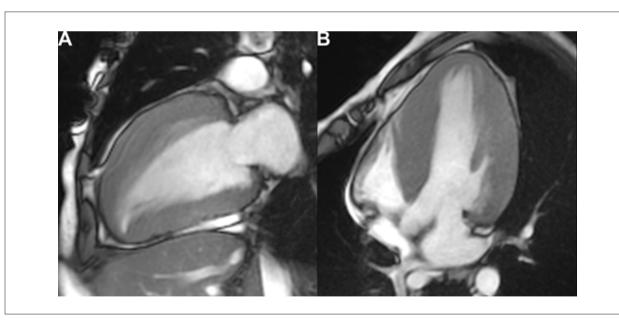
Cine-B-TFE sequences of cardiovascular magnetic resonance imaging. The basal septum is the area with most accentuated hypertrophy, yet there is diffuse involvement of the left ventricle. (A) Horizontal long axis view. (B) Vertical long axis view.
